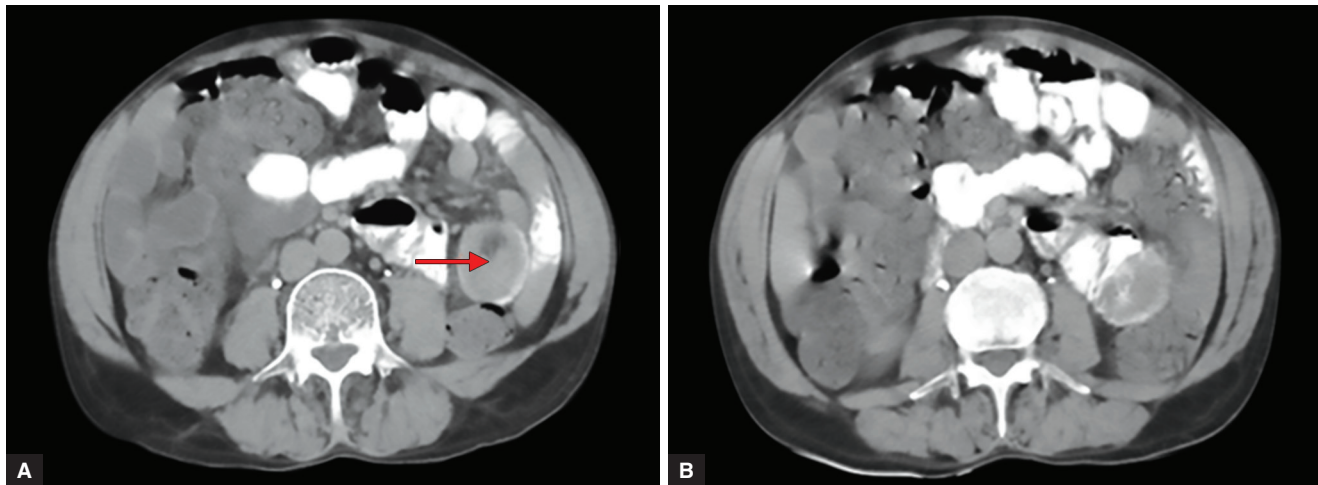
CT (A—plain) and (B—contrast) shows a well-defined lesion giving target appearance (short arrow) involving the distal ileum and colon. A well-defined lesion of soft tissue attenuation (long arrow) later proven to be leiomyoma was found to be the cause of intussusception. Case 2: A 37-year-old female presented with acute pain abdomen
